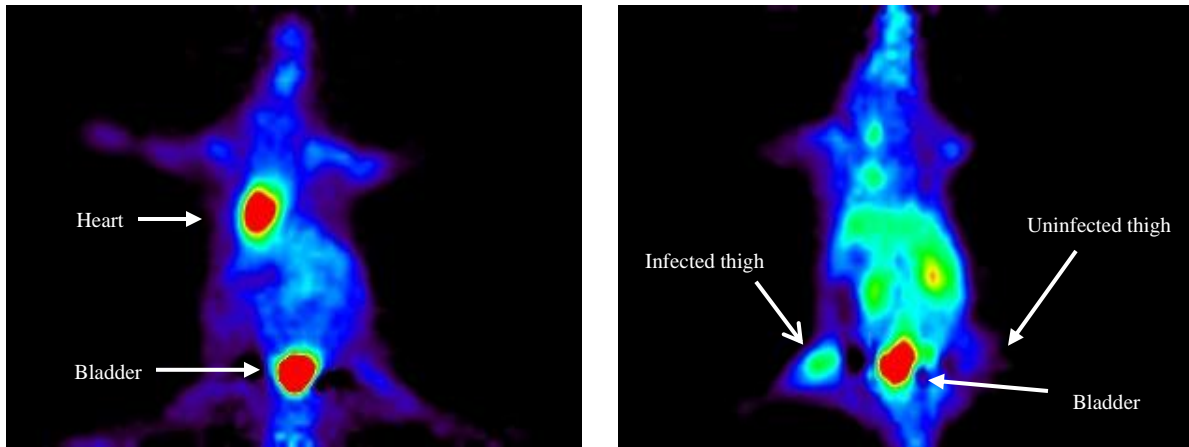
[¹⁸F]FDG imaging of *S. aureus* thigh infection model (slice, not projection, summed from 0-120 min).
